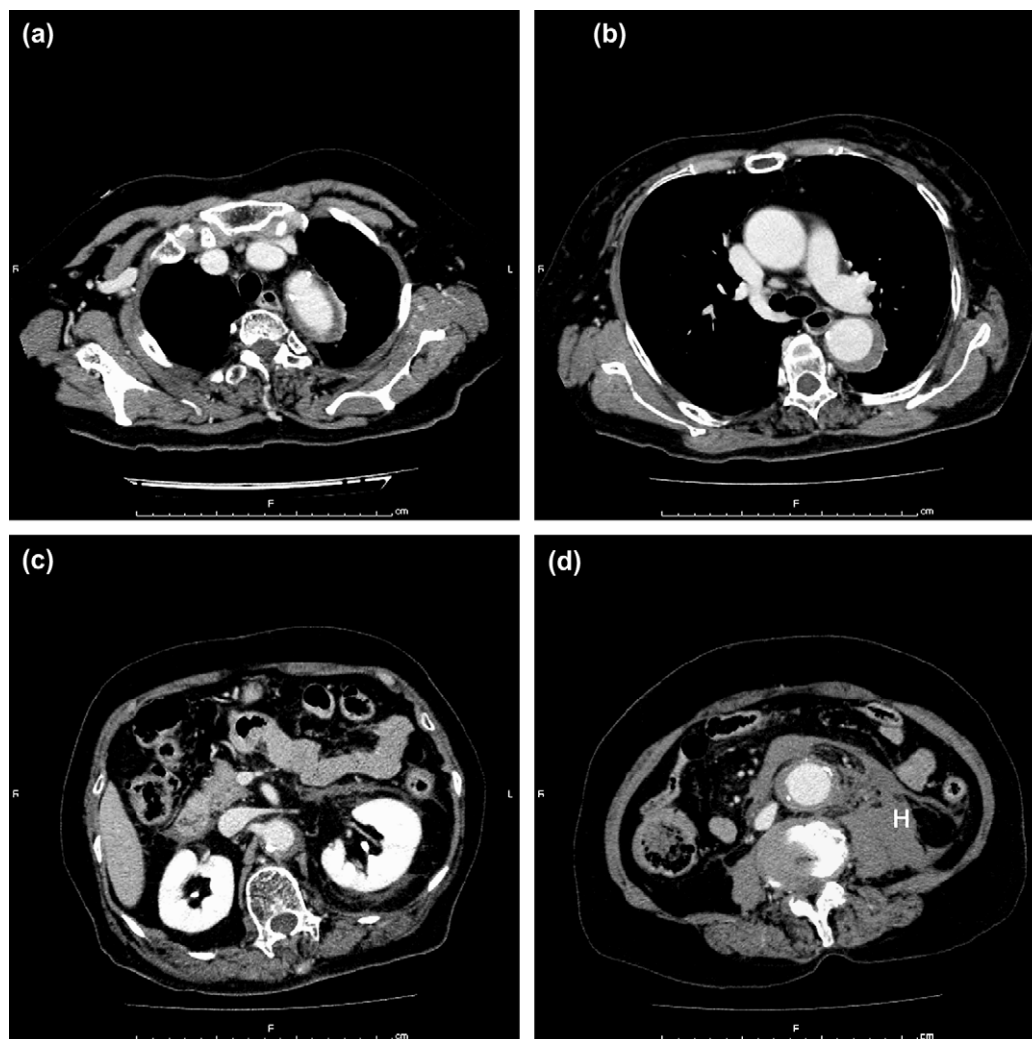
(a) Computed tomograph on admission at the distal arch level. This documents the absence of ulcer like projections (ULP). (b) Computed tomograph on admission at the carina level. Again, no ULP are present. (c) Computed tomograph on admission at the right renal artery level showing thrombo-occluded false lumen. (d) Computed tomograph on admission around the previous suture line showing a thin hematoma around a previously implanted graft for an infrarenal abdominal aortic aneurysm. There is evidence of retroperitoneal bleeding (H).
